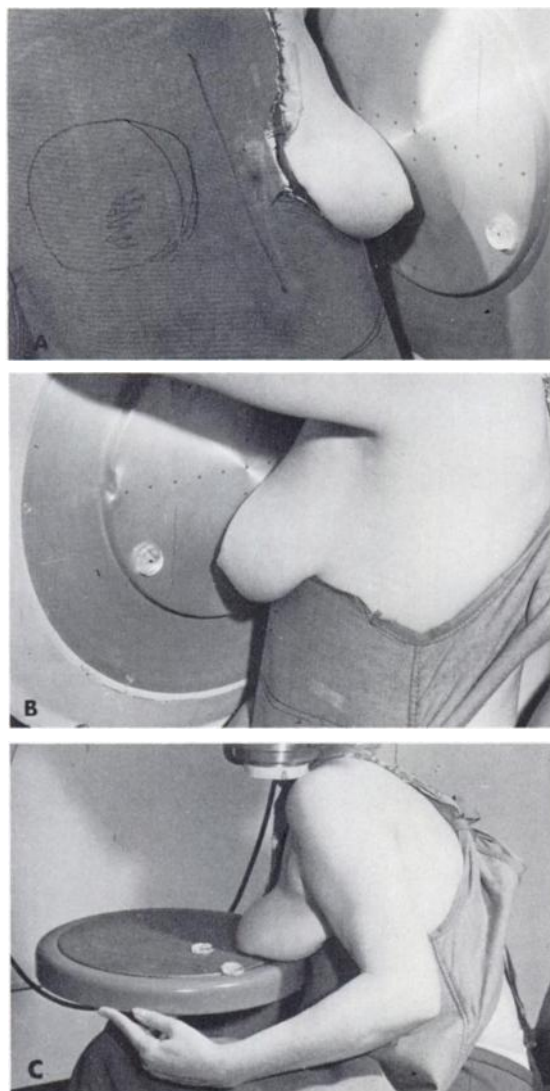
Positioning of patient for lateral (A), medial (B), and craniocaudal (C) gamma camera breast scintigraphy. Cobalt-57 markers note nipple and axillary regions. Craniocaudal view is omitted in ^{67}Ga -citrate breast scintigraphy.
